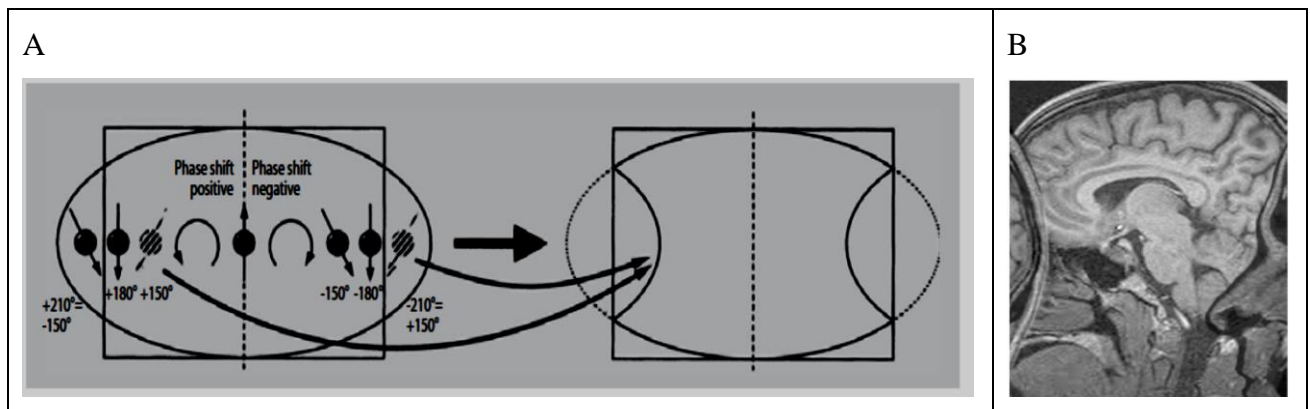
Aliasing artefact concept. Areas outside the defined FOV are assigned the same phase shift as areas within the FOV and are therefore superimposed (A). A sagittal brain MR image shows the front parts of the head (the nose and mouth) are folded over the posterior part of the head. Similarly, the posterior part of the head (the occipital part) is folded over the front part (B). (adapted from (Koechli et al., 2006) (A) and (Westbrook et al., 2011) (B)).
